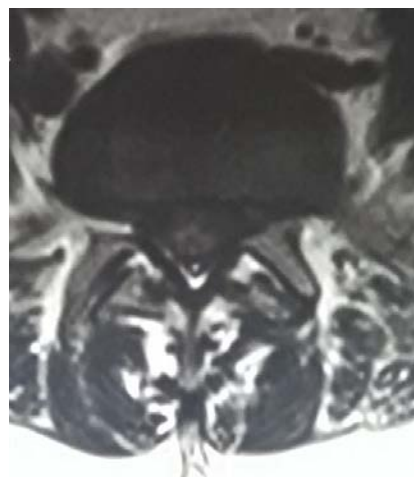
MRI lumbosacral spine axial section showing left paracentral disc herniation at L5-S1 level
